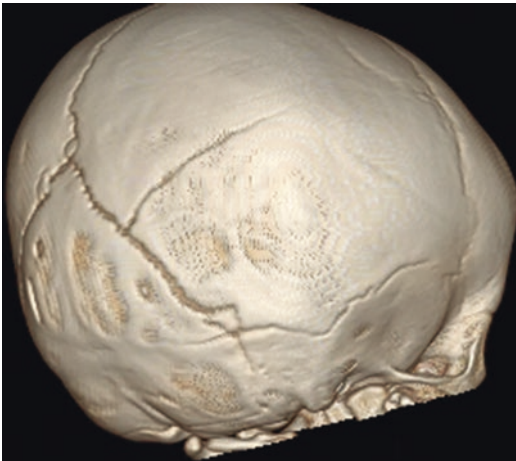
3D reformatted CT scan demonstrating a right-sided parietal bone fracture
